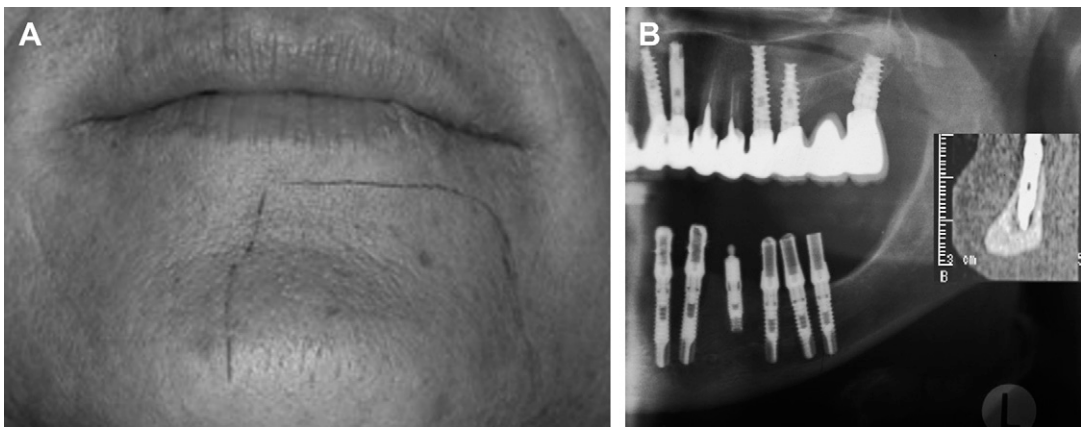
Pain and neurosensory deficit after dental implants. (A) Mapped area of pain and disturbed sensation. (B) Implant placement. Insert is a CT section of an implant causing damage to the inferior alveolar nerve.
